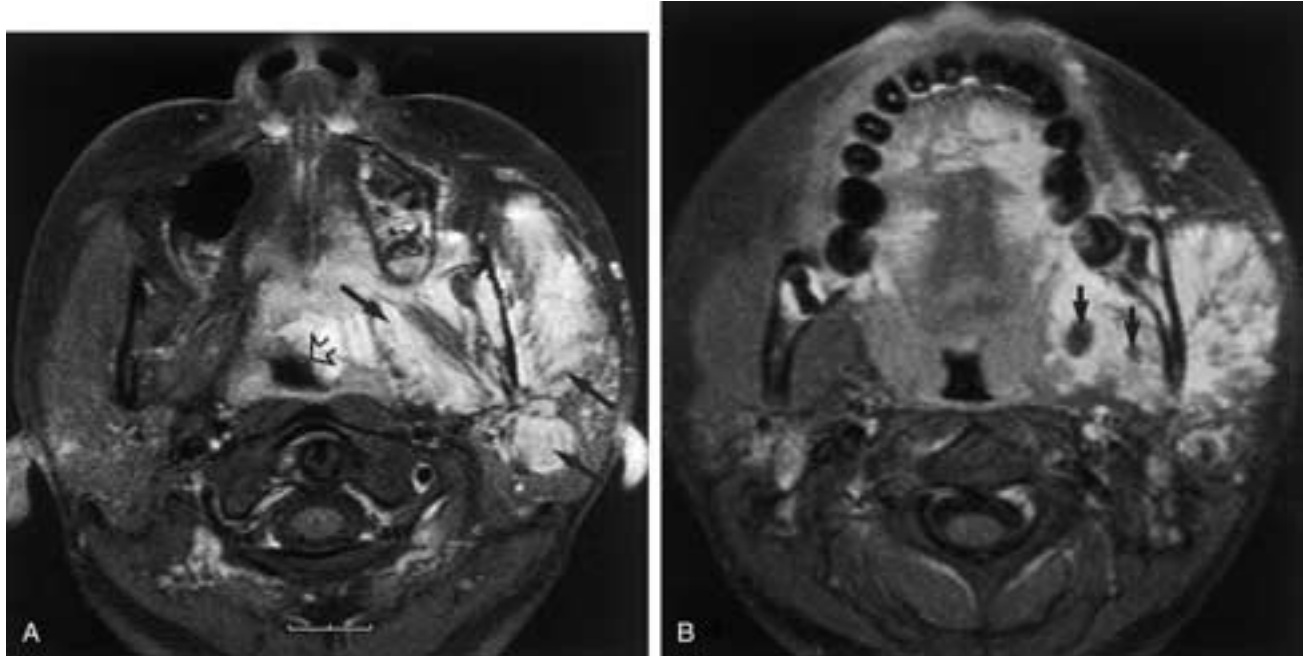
VM in a 13-year-old girl. Axial fat-suppressed, contrast-enhanced T1-weighted MR image (A) reveals a multiseptated enhancing mass (arrows) within the left muscles of mastication, the mandible, parotid space, parapharyngeal space, soft palate, and pharynx. There is distortion of the airway (open arrow). B, Phleboliths (arrows) are present.
